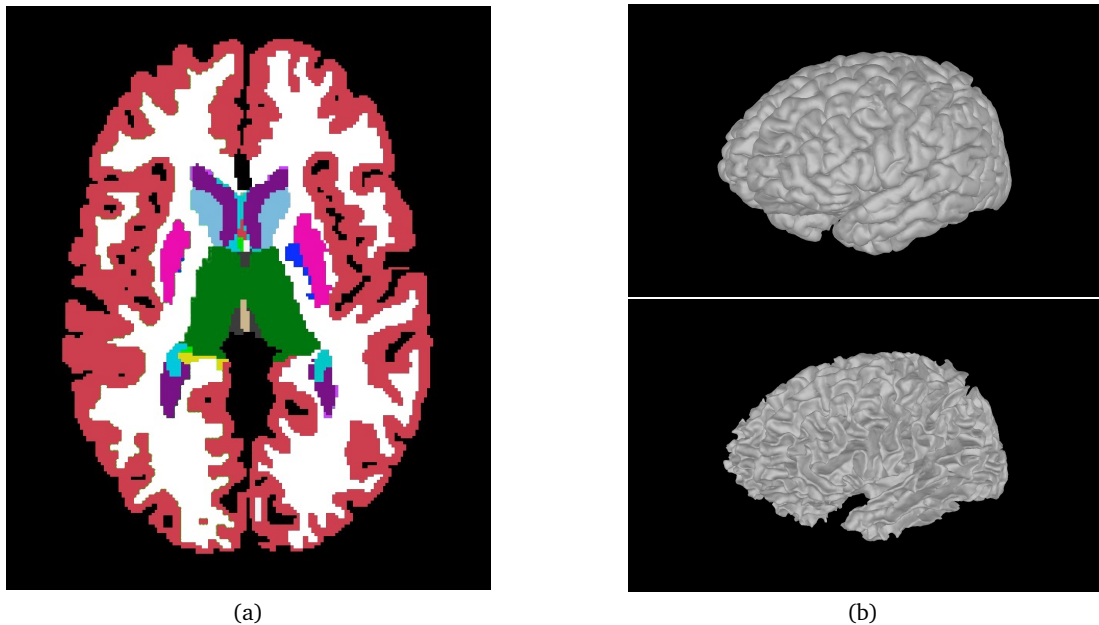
Result of Freesurfer segmentation and reconstruction procedures: (a) labeled MRI axial cross-section after the Freesurfer matter segmentation procedure. Each color represents one intra-cerebral anatomical structure, in total about 40 structures. Image produced with 3D Slicer (<http://slicer.org/>), (b) gray (up) and white (down) matter surface reconstruction.
